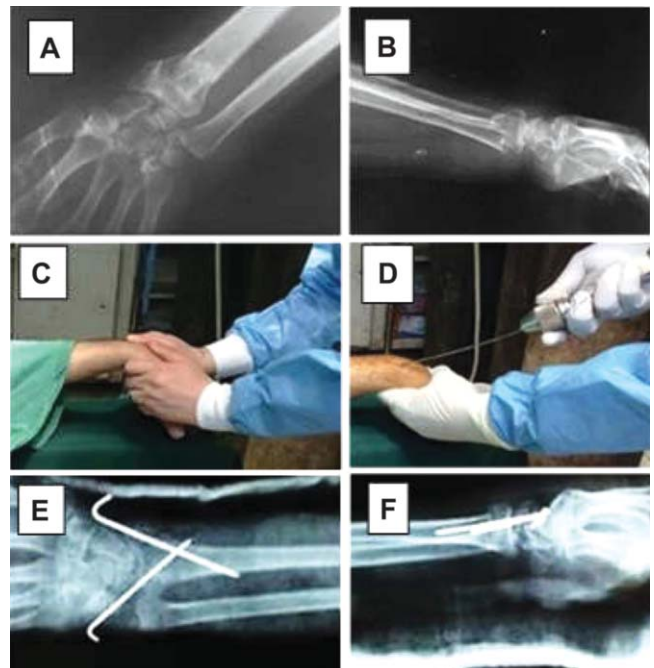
A-B) Pre-operative X-ray, C-D) Closed reduction and percutaneous k.wire fixation, E-F) AP and lateral postoperative X-ray (Al Shahwanii, Qaryaqos. Al Yarmook Teaching Hospital 2017).
